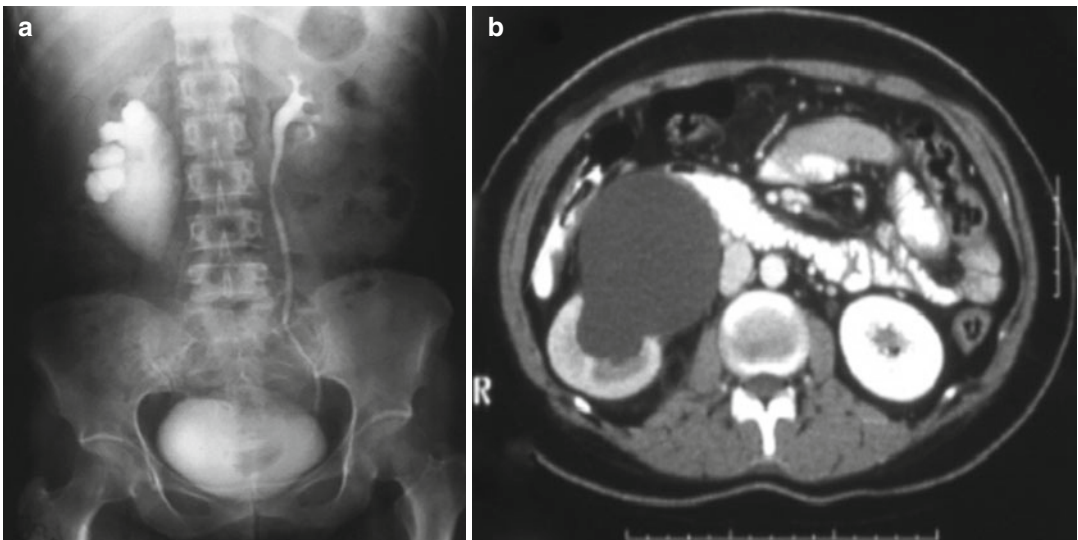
IVP (a) and axial CT scan (b) images demonstrating a right UPJO and normal left kidney
